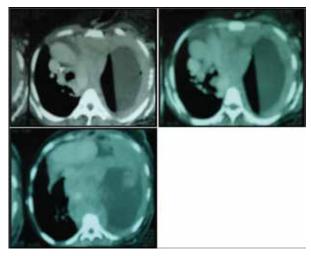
(a,b,c): Chest CT
